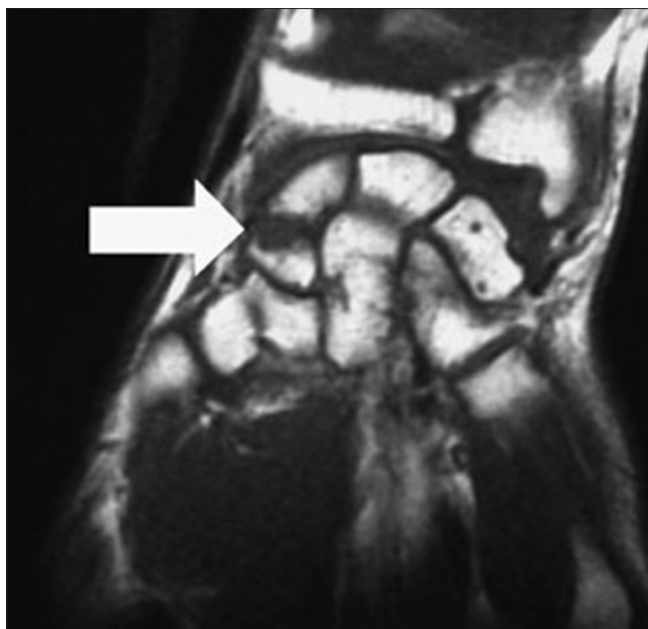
Magnetic resonance imaging of patient with clinically suspected and occult scaphoid fracture with anatomical snuff box tenderness and negative radiographs showing Scaphoid fracture line (white arrow)
